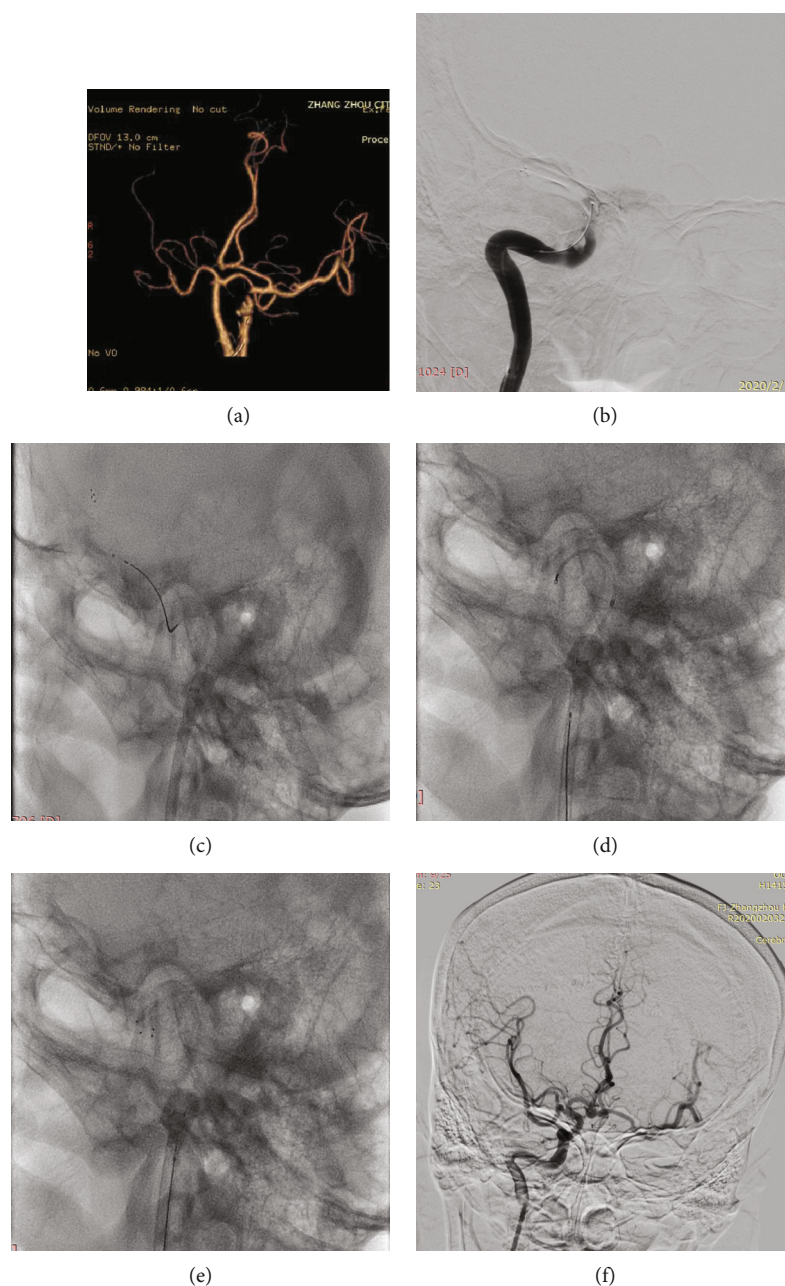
An elderly presented with left hemiparesis and a history of atrial fibrillation postcardiac valve replacement. The patient regularly took warfarin, and admission NIHSS was 18. (a) Computed tomography angiography (CTA) shows total occlusion of the right ICA occlusion and the anterior communicating artery open; the right anterior cerebral artery is supplied by the left ICA. (b) A Solitaire 6-30 mm stent was unsheathed at the occlusion site (shown as a black arrow). DSA showed ICA intracranial segment occlusion with a large clot burden, and the CBS was 3. (c) After at least 3 minutes, the balloon (shown as a black arrow) was inflated to arrest the anterograde flow from the ICA. Then, the fully deployed Solitaire stent was partially resheathed, and together with the delivery microcatheter, it was gently pulled back under continuous suction achieved with a syringe. This procedure is called primary clot retrieval. (d) The BGC remained inflated for there is no blood out of BGC, and continuous suction was applied via a syringe; the microcatheter and stent are advanced together directly into the site, which is close to the distal tip of the BGC. (e) The stent is unsheathed at the site close to the distal tip of the BGC, and then the stent together with the delivery microcatheter is retrieved back under continuous suction. This procedure is called rescue clot retrieval. (f) Rescue clot retrieval is repeated until there is blood flow without a thrombus through the BGC; contrast is gently injected via the BGC to confirm that successful reperfusion is achieved. The balloon is deflated, and DSA shows that the right ICA is totally patent and the anterior communicating artery is open; the bilateral MCA and ACA are supplied by the right ICA. NIHSS: NIH stroke scale; CTA: CT angiography; DSA: digital subtraction angiography; ICA: internal carotid artery; BGC: balloon guide catheter; CBS: clot burden score; MCA: middle cerebral artery; ACA: anterior cerebral artery.
